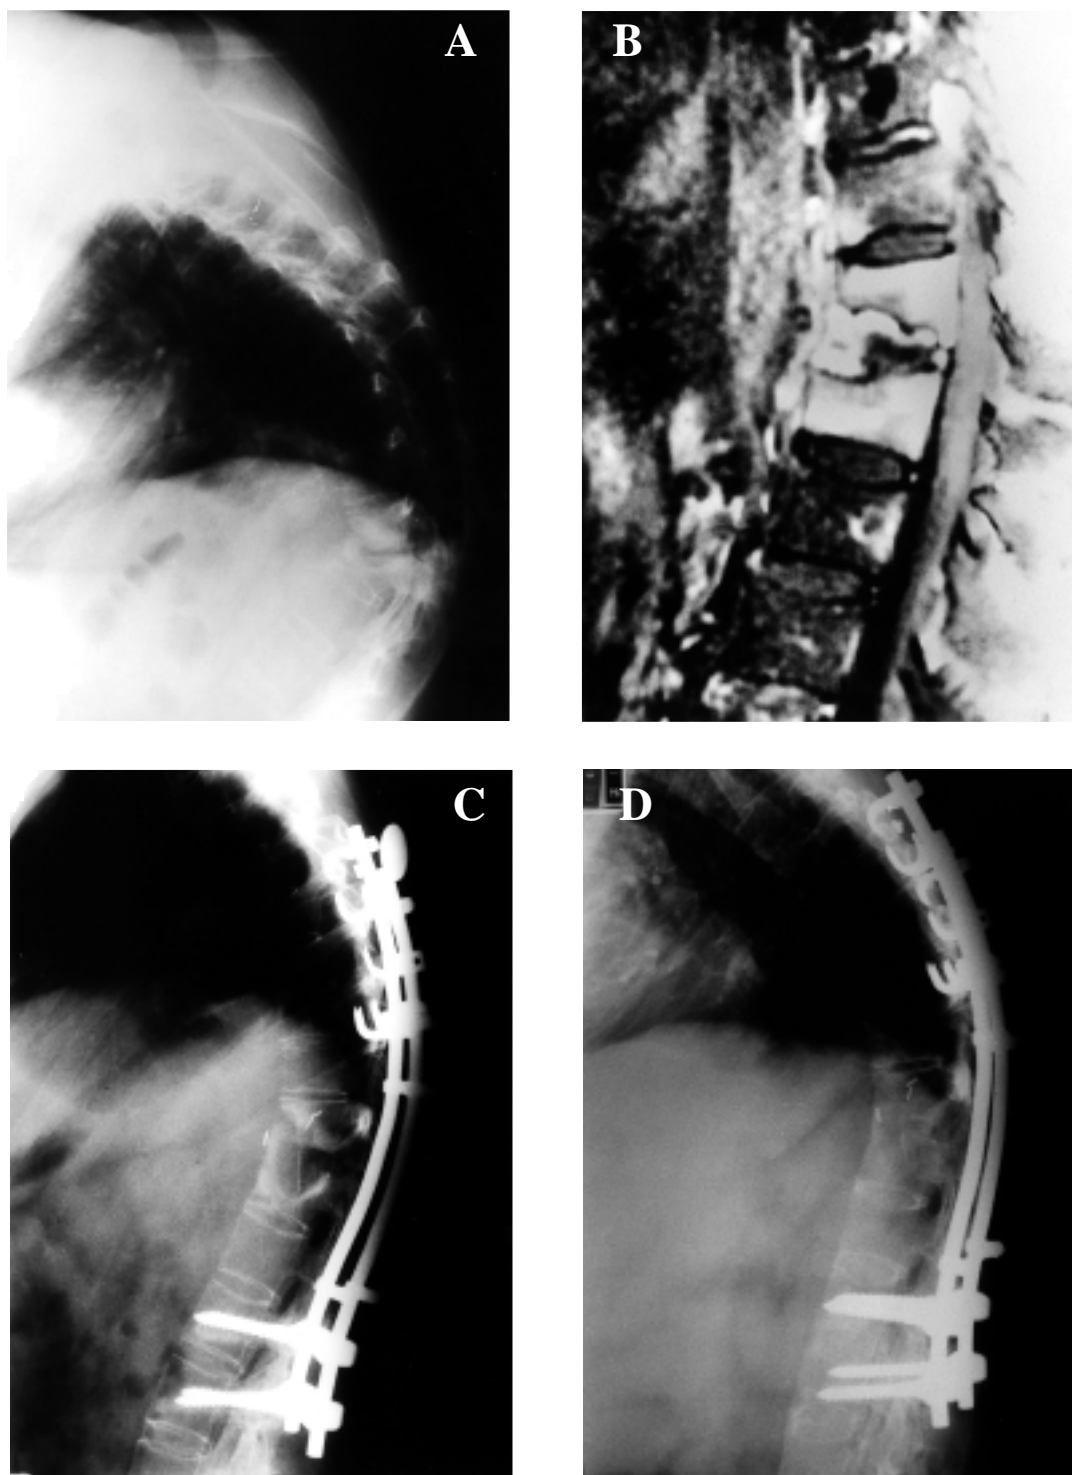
Case 8. (A) Preoperative lateral view; (B) MRI (T1-weighted image with enhancement) showing high signal intensity at the lesion site; (C) postoperatively, lateral view; (D) latest follow-up, lateral view.
